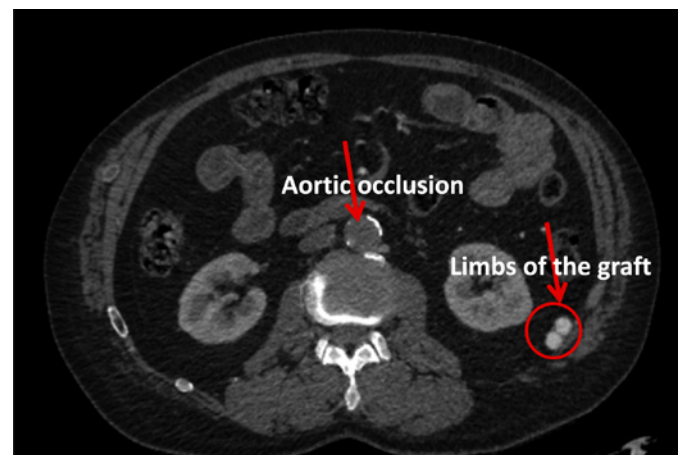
Retroperitoneal course of the graft as displayed in a postoperative axial CT image.
